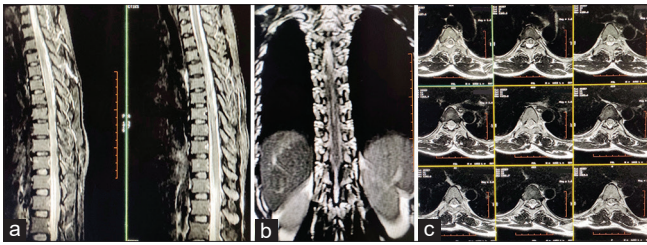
MRI of spine with contrast revealed longitudinally extensive altered intramedullary intensity hyper in T2 (a) mid-sagittal, (b) coronal, C-axial (D3 to D7)) from D3 to distal cord and conus (A), predominantly involving the central portion of cord (c)
